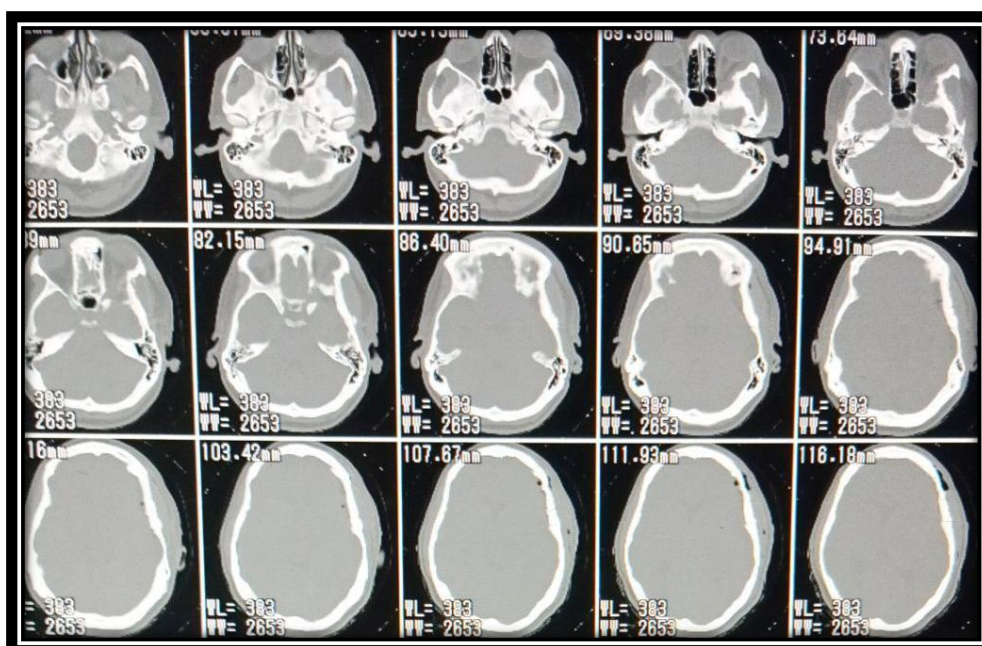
Axial view of CT brain post-operative
